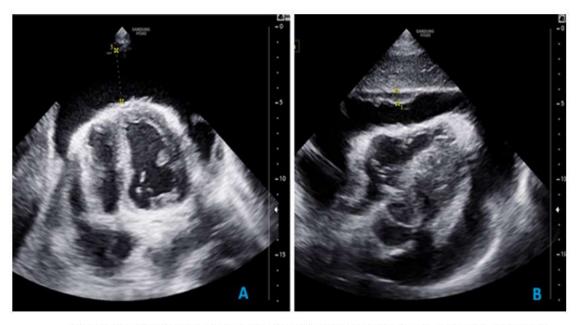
Transthoracic echocardiographic views demonstrating pericardial effusion.
